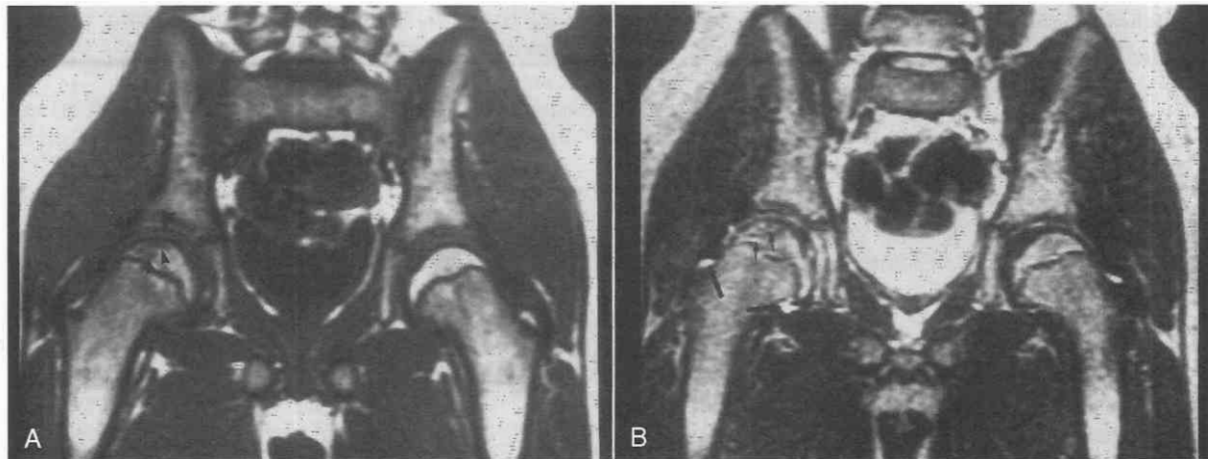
Legg-Calvé-Perthes disease in a 7-year-old boy with recent onset of right hip pain. Pelvic radiographs (not shown) were normal. A, Coronal T1-weighted MR image shows bandlike areas of marrow replacement in the superolateral aspect of the right femoral head (*small arrowheads*). Overlying cartilage (*large arrowheads*) appears intact, and the femoral head is well covered by the acetabulum. B, Coronal T2-weighted image reveals the areas of avascular necrosis to be largely high signal intensity (*small arrows*), consistent with class C changes (fluid-like). Minimal associated joint effusion is also present (*large arrows*).
